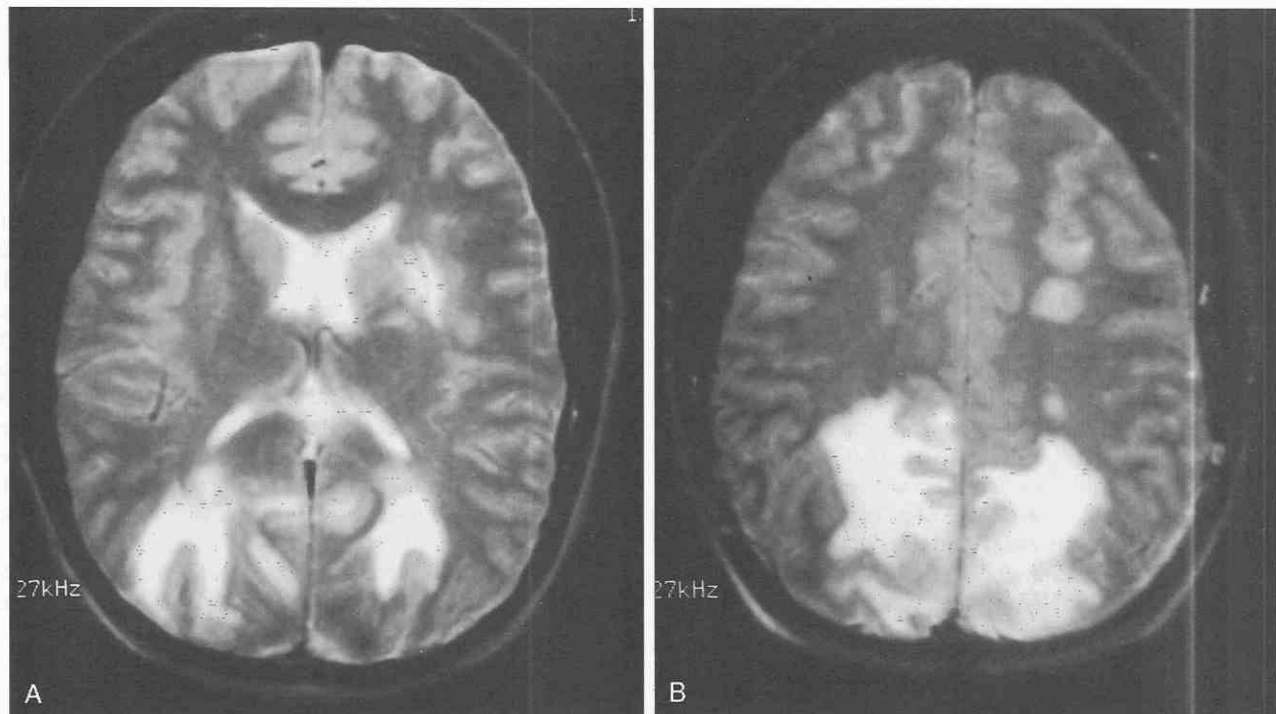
Eclampsia (reversible posterior leukoencephalopathy syndrome). A and B, T2-weighted MR axial images show the predominantly occipital white matter swelling. Cortical and left basal ganglia involvement are present.
